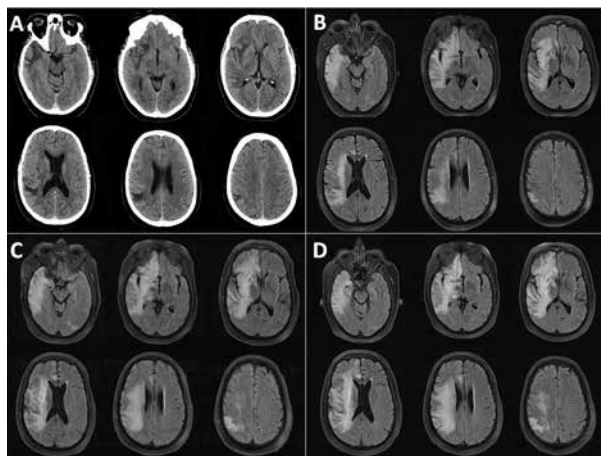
Serial neuroimaging done on presentation and following treatment with pembrolizumab, showing radiographic progression correlating with clinical deterioration.
